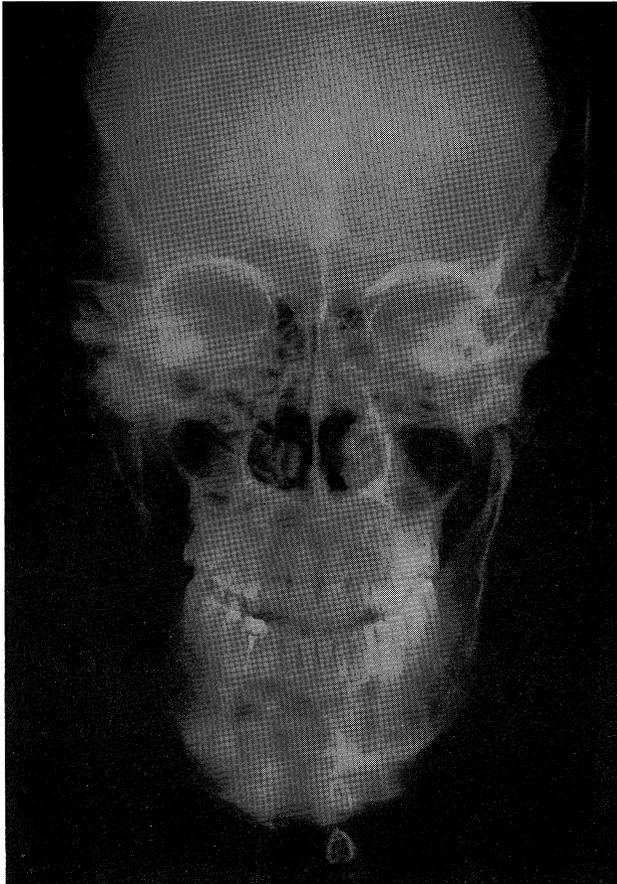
X-ray picture of the mandible.
